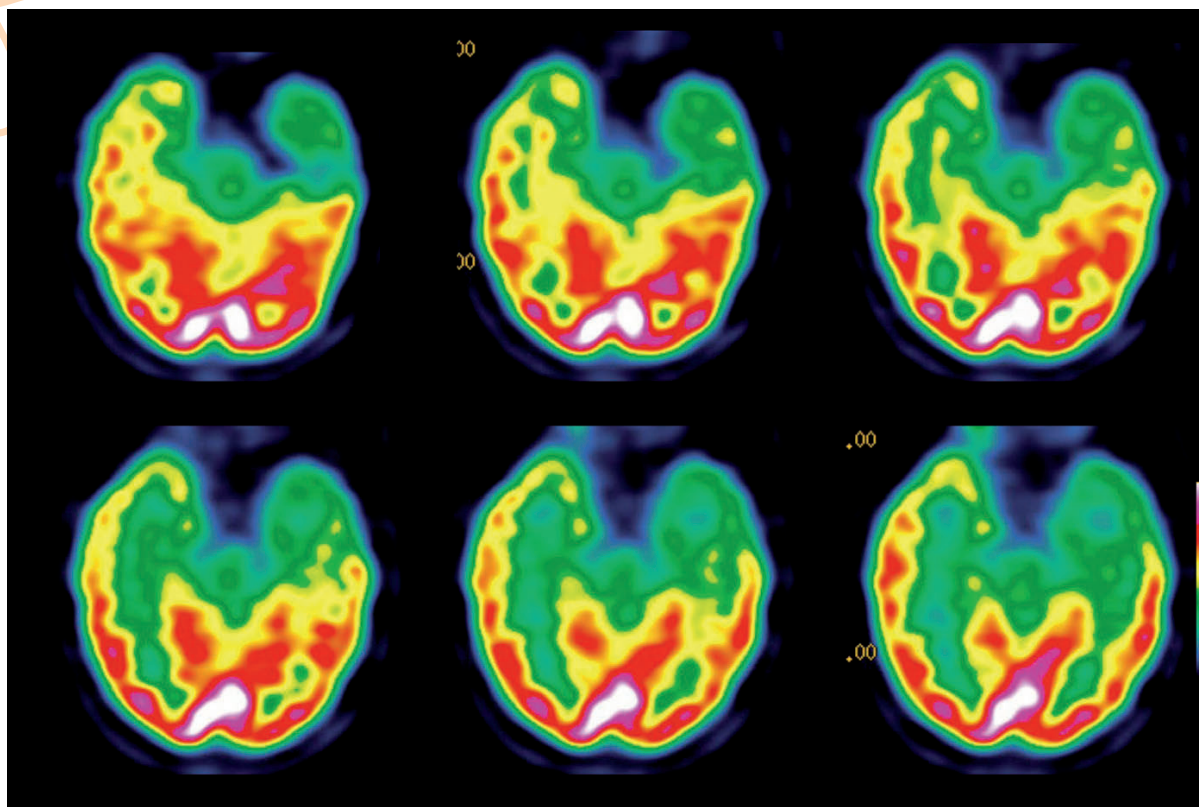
Interictal FDG PET scan in a patient with TLE, showing hypometabolism involving the left temporal lobe. The hypometabolism is more pronounced in the temporopolar region but involves the mesial part of the temporal lobe and extends to the lateral part (axial image in the hippocampal plane)
